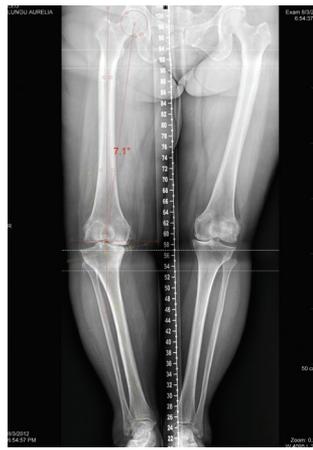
Standing X-ray for lower limb axis preoperative for the right knee arthroplasty.
